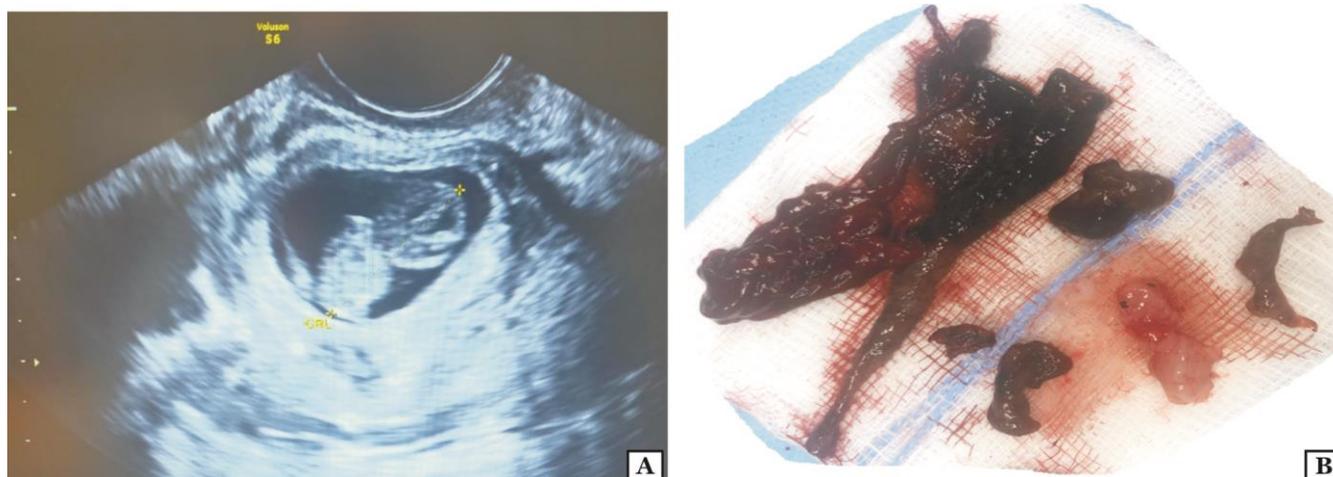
2. Transvaginal ultrasound showing crown rump length (CRL) of the fetus (A). Surgical removal of the fetus and the placental tissue (B).
